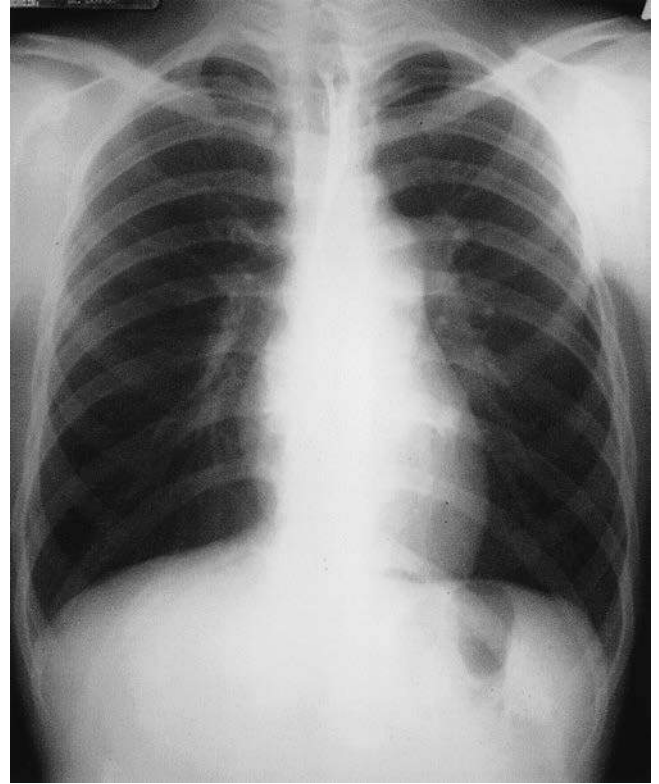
Frontal chest radiograph of a patient with moderate stenosis showing dilation of the left pulmonary artery. Heart size and lung vascularity are normal.
